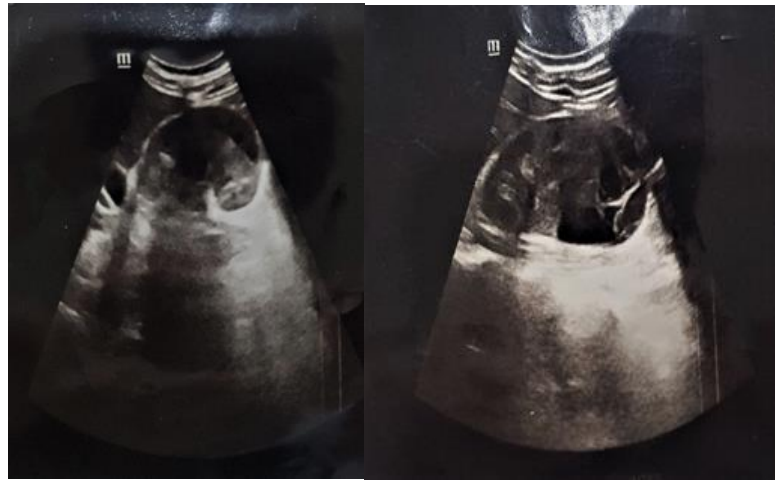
Ultrasound images of the patient
